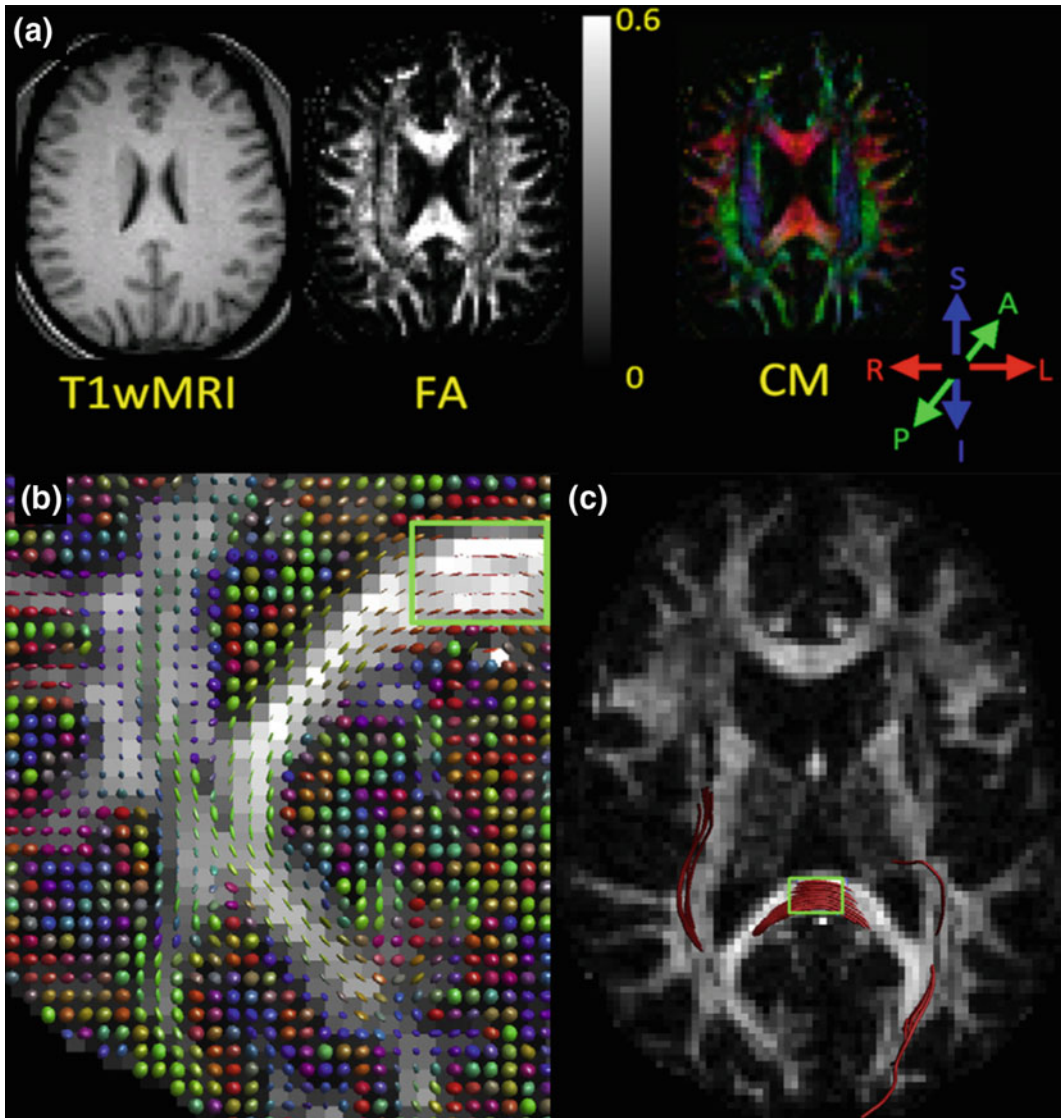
a *left* T1-weighted structural magnetic resonance tomographic image (T1wMRI) depicting a transversal slice of a human brain spatially aligned to DTI-images presented as follows: *middle* Fractional anisotropy (FA) image: Brain regions showing high FA-values, thus revealing well-organized parallel axon arrays, show bright gray-scale values. *Right* DTI color map (CM) image depicting the spatial orientation of the principal eigenvector (principal direction of water molecule diffusion) across 3-dimensions: R-L (*red*): right-left; S-I (*blue*): superior-inferior; A-P (*green*): anterior-posterior. The
